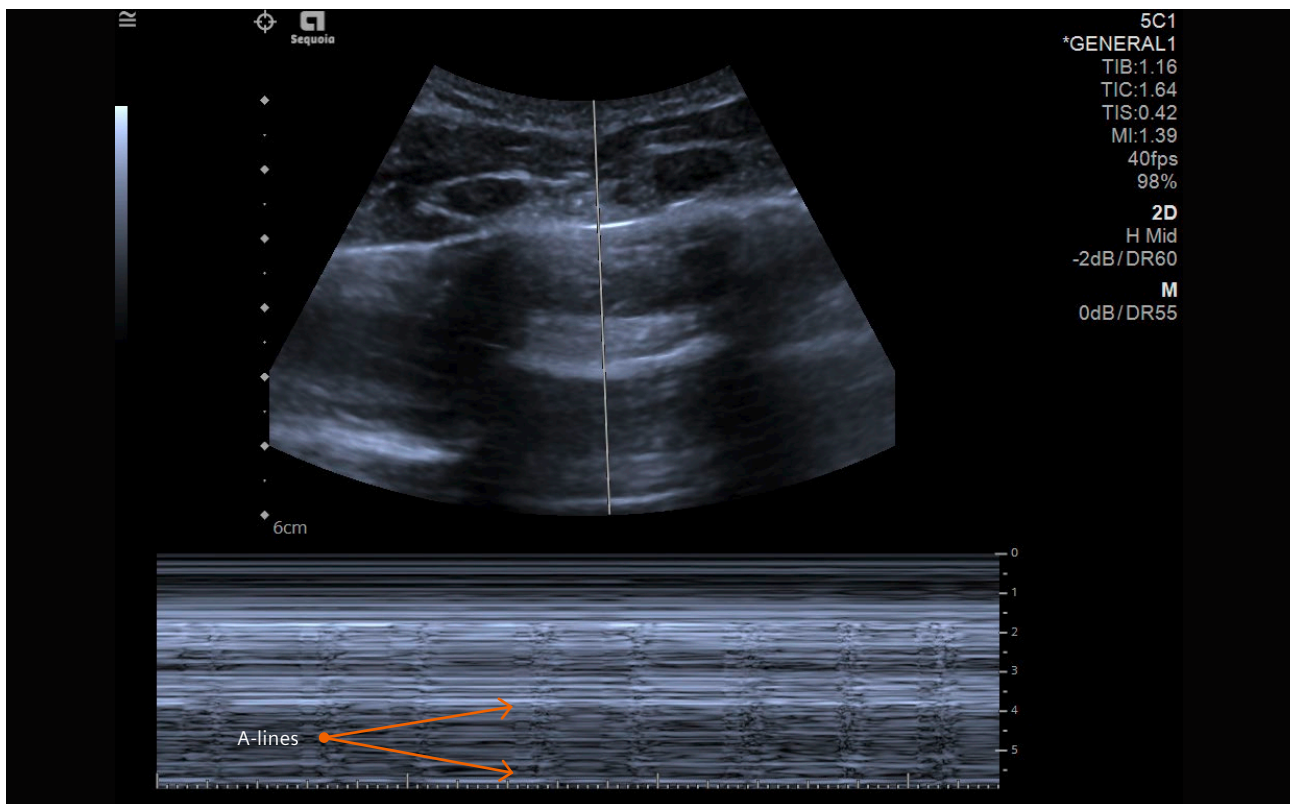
Ultrasound image demonstrating A-lines using a curved transducer. The A-lines are clearly visible on the M-mode as bright white lines.
